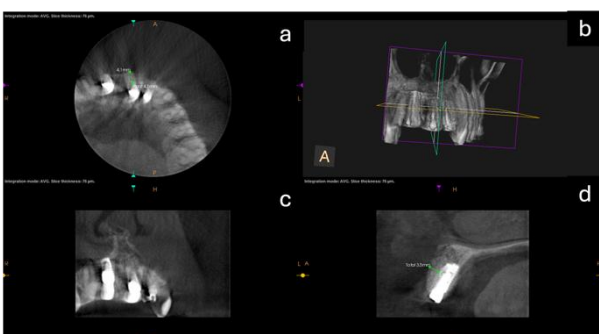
Two-week postoperative CBCT assessment of the AutoBT-grafted anterior maxilla. (a) Axial slice showing a 4.1 mm bucco-palatal ridge width (green calibre). (b) 3-D volume-rendering with re-oriented slicing plane. (c) Sagittal slice confirming preservation of the labial plate. (d) Coronal view at the former tooth-21 sockets demonstrating graft fill and a 3.6 mm ridge width.
